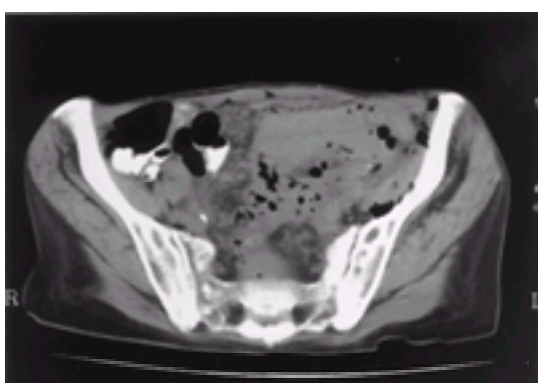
CT scan showing diverticulitis with retroperitoneal gas within iliacus muscle.
